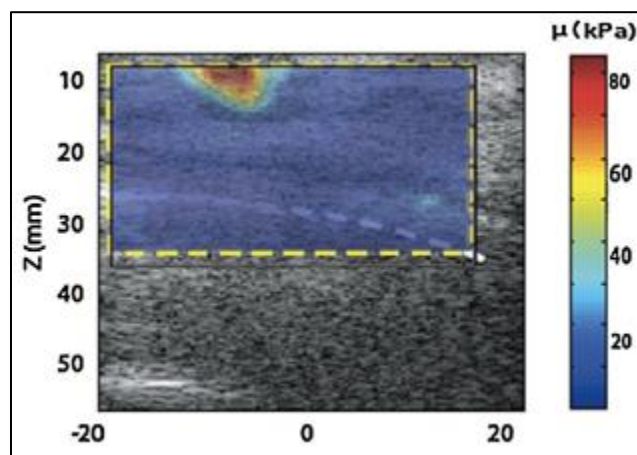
An adenocarcinoma appears stiffer in the elasticity image and darker in the ultrasound image, (Gennisson et al., 2013).
